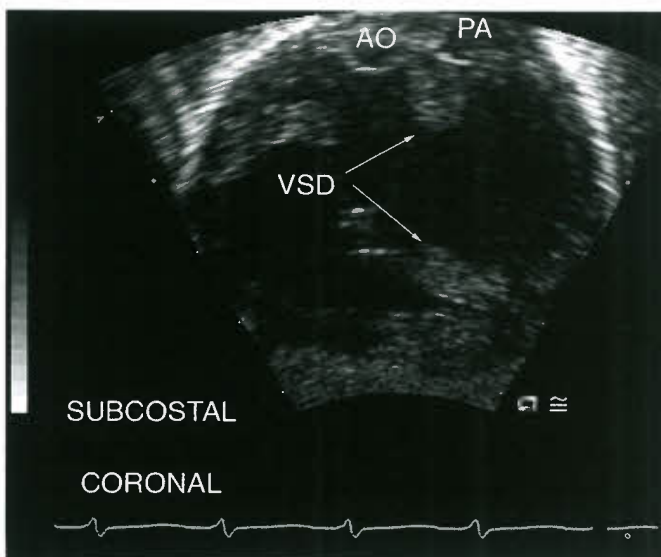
Echocardiogram of DORV with noncommitted VSD. Subcostal coronal view demonstrates the VSD (arrows mark the crest of the interventricular septum and the tip of the conal septum), which is remote from both great arteries due to bilateral conus. VSD, ventricular septal defect; AO, aorta; PA, pulmonary artery.
